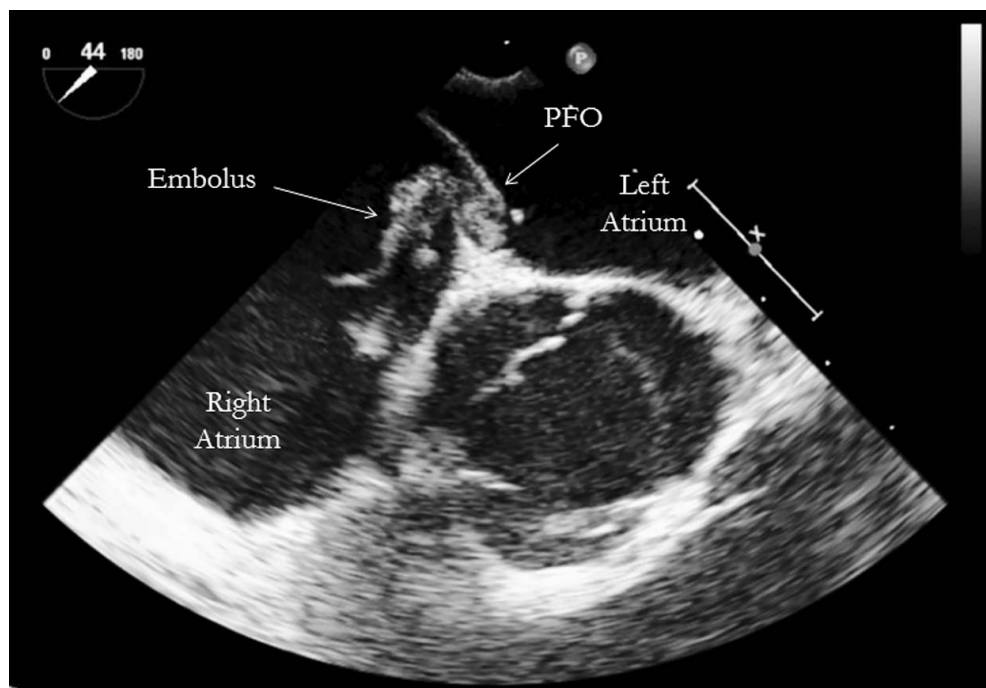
Short-axis echocardiographic view demonstrates a large thromboembolism-in-transit across a patent foramen ovale (PFO).
